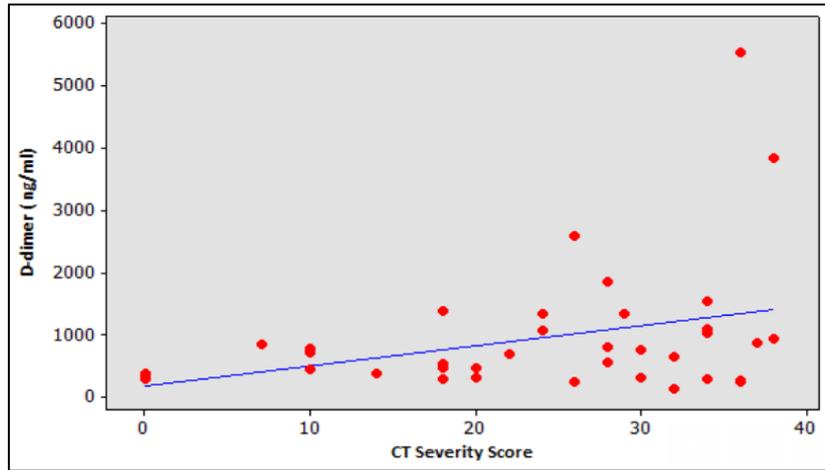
Graph showing distribution of D -dimer values with CT Severity Scores.
